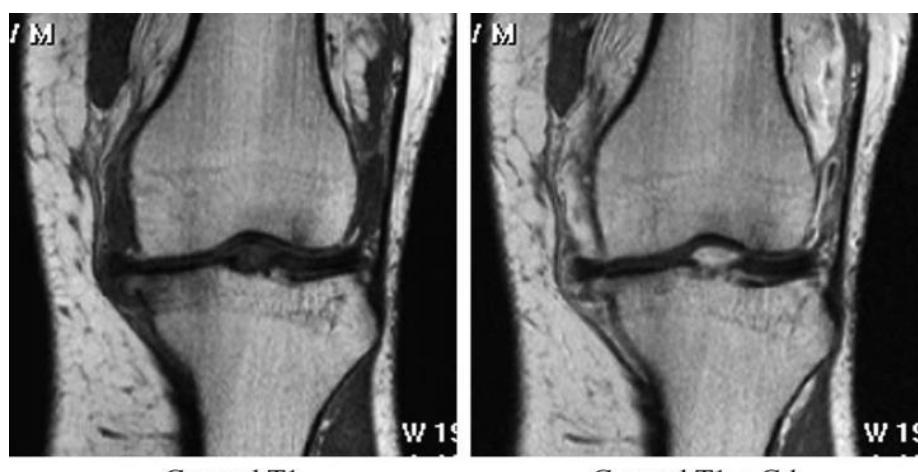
Coronal section MRI images of an Osteoarthritic knee (with and without use of Gadolinium contrast agent)
